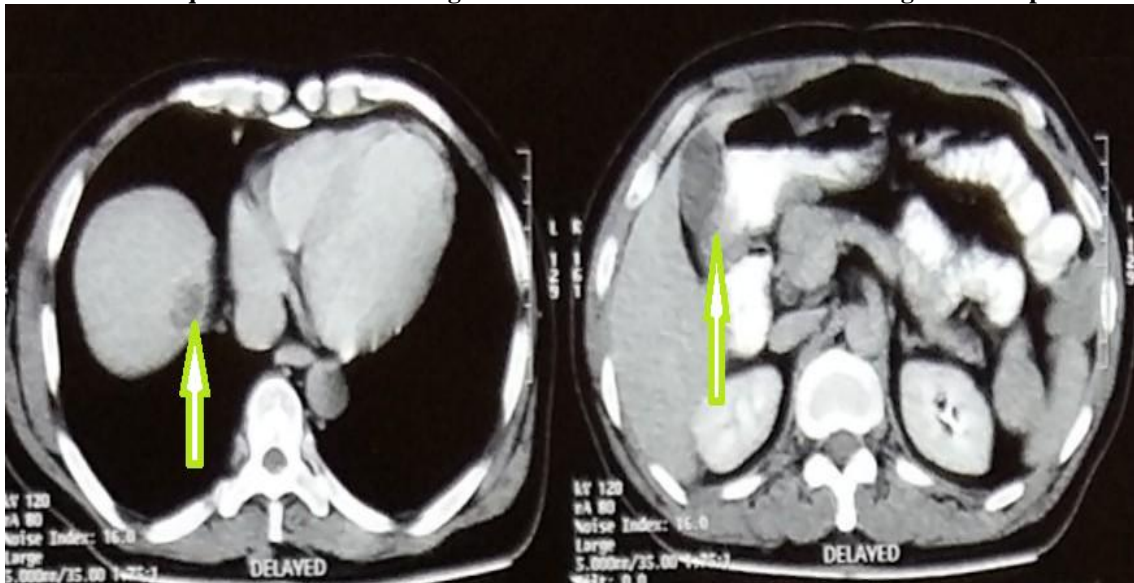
Contrast enhanced CT (Oral+i.v contrast) showing multiple heterogeneously enhancing irregular hypo to isodense lesions in liver. This was a case of multifocal Hepatocellular carcinoma in a Human Immunodeficiency Virus (HIV)positive young male patient
